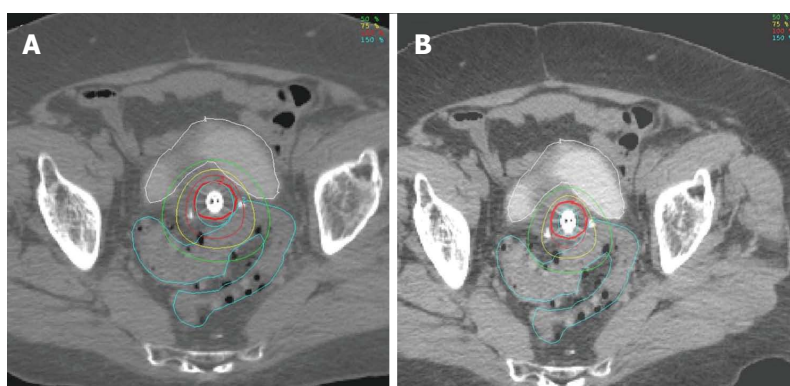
Conventional 2D point dose brachytherapy planning over doses critical organs for small cervix. Magnetic resonance imaging planning images showing over-dosage of critical organs with point-A image based prescription (A) for patient with small cervix which is improved with image-based brachytherapy (B).
